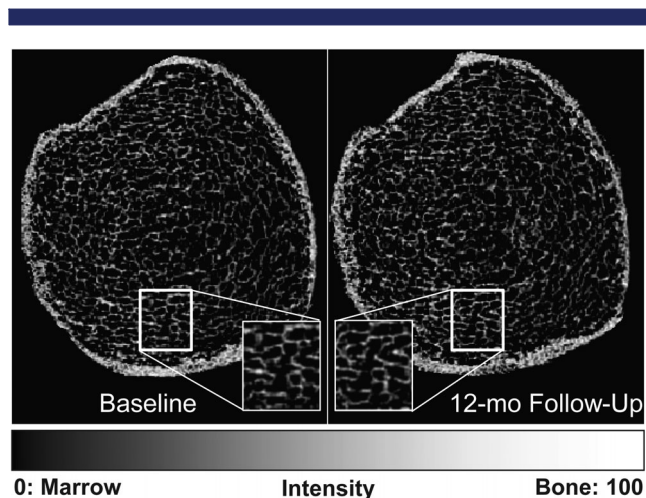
MRI-derived bone volume fraction maps of the distal tibia of a representative participant taken 12 months apart show the ability to capture matching bone microstructure using prospective registration. Regions are magnified to demonstrate matched pairs. These 3D maps serve as input into the finite-element model, yielding a measure of stiffness in GPa and thus strength.
